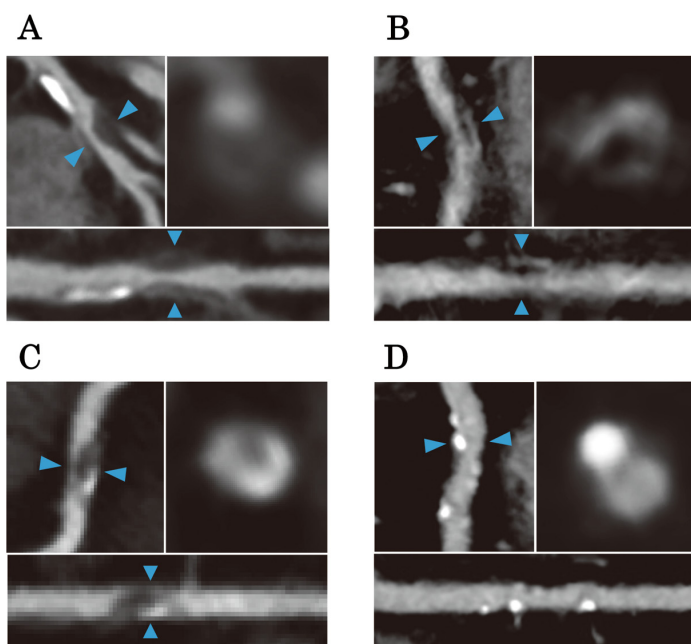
Representative images of each high-risk plaque feature (HRPF) on computed tomography angiography (CCTA). (A) Positive remodeling (blue arrowheads). The remodeling index was 1.26. (B) Very low attenuation plaque (blue arrowheads). The minimum CT value within the low-attenuation area was -10 HU. (C) Napkin-ring sign (blue arrowheads). (D) Spotty calcification (blue arrowheads). Left upper panels show curved multiplanar reconstruction images, whereas right upper panels show cross-section images of the areas indicated by the blue arrowheads. Lower panels show straight multiplanar reconstruction images.
